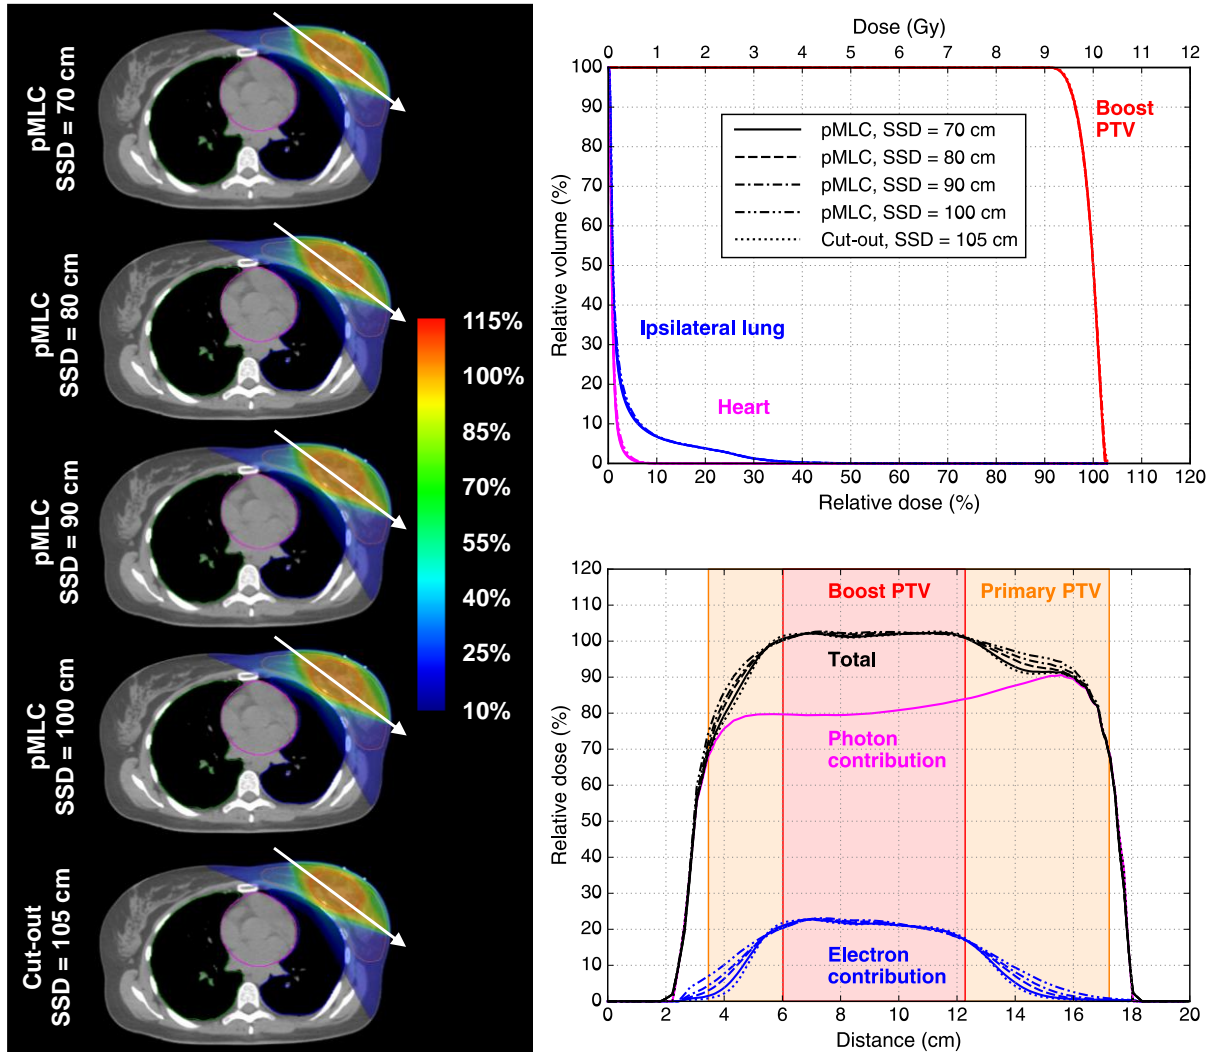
Dose distributions (left) and DVHs (top right) of TrueBeam 12 MeV 1E2X plans created for the left breast boost case and dose profiles (bottom right) indicated by a white arrow on the dose distributions. The legend of the DVHs also applies to the dose profiles. The contours of the boost PTV (red), primary PTV (orange), ipsilateral lung (blue), contralateral lung (green) and heart (magenta) are visible on the transversal CT images.
